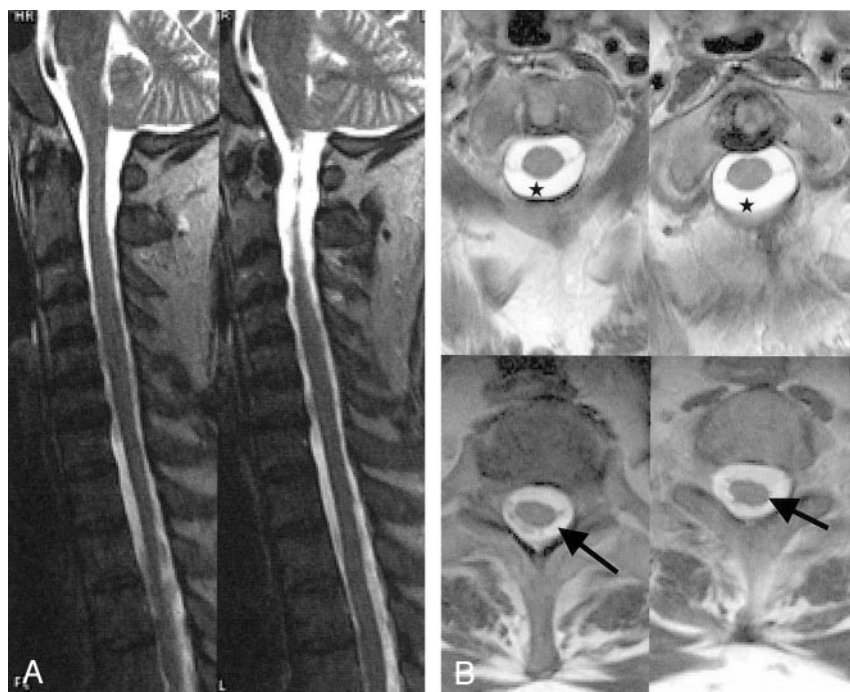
Follow-up MR images obtained 1 month later, after treatment.
